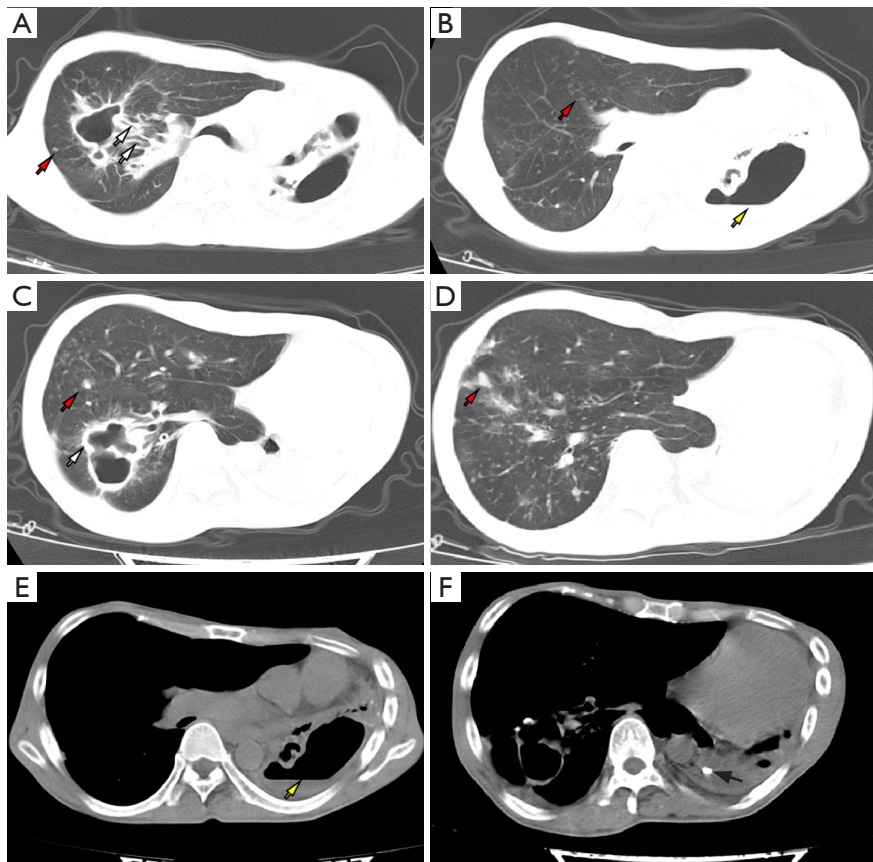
CT of a cases of pre-extensively drug-resistant tuberculosis (male, 36 years old). The left thoracic cavity is partially collapsed, the mediastinum shifted to the left (A-F). Multiple thick-walled cavities in the right lung, thickened and dilated draining bronchi are seen in the proximal end (A,C) (white arrows). The left lung is damaged, and an air-fluid level is seen in the damaged cavity (B,E) (yellow arrow). Multiple small nodules, cords, and tree-in-bud signs are seen in the right lung (A-D) (red arrows). Lesions seen in the right lung and nodular calcification in the left pleura (F) (black arrow). Bilateral pleural thickening, small amount of wrapped effusion in the left thoracic cavity (F). CT, computed tomography.
